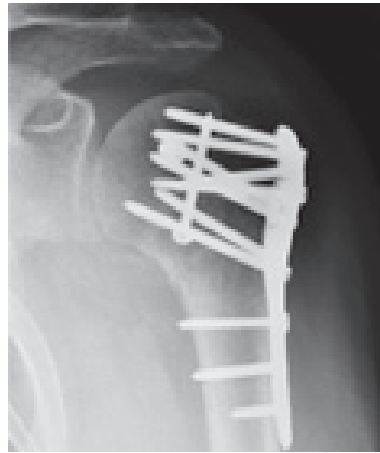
X-ray presenting an open reduction and internal fixation with LCP.
